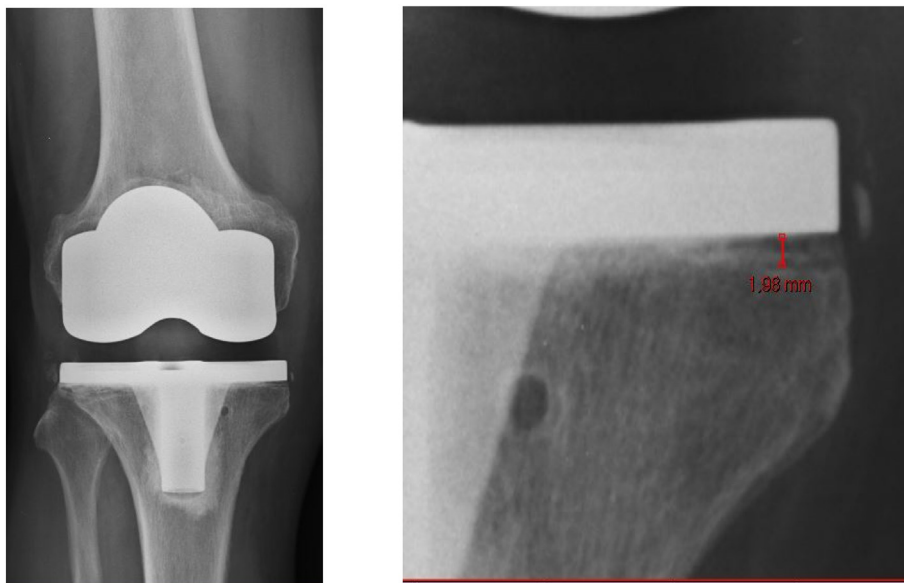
X-Ray images at seven years of follow-up: the radiolucency area can be observed localized in zone 1 on the medial tibial plate. Once measured, it still appears as being <2 mm.
